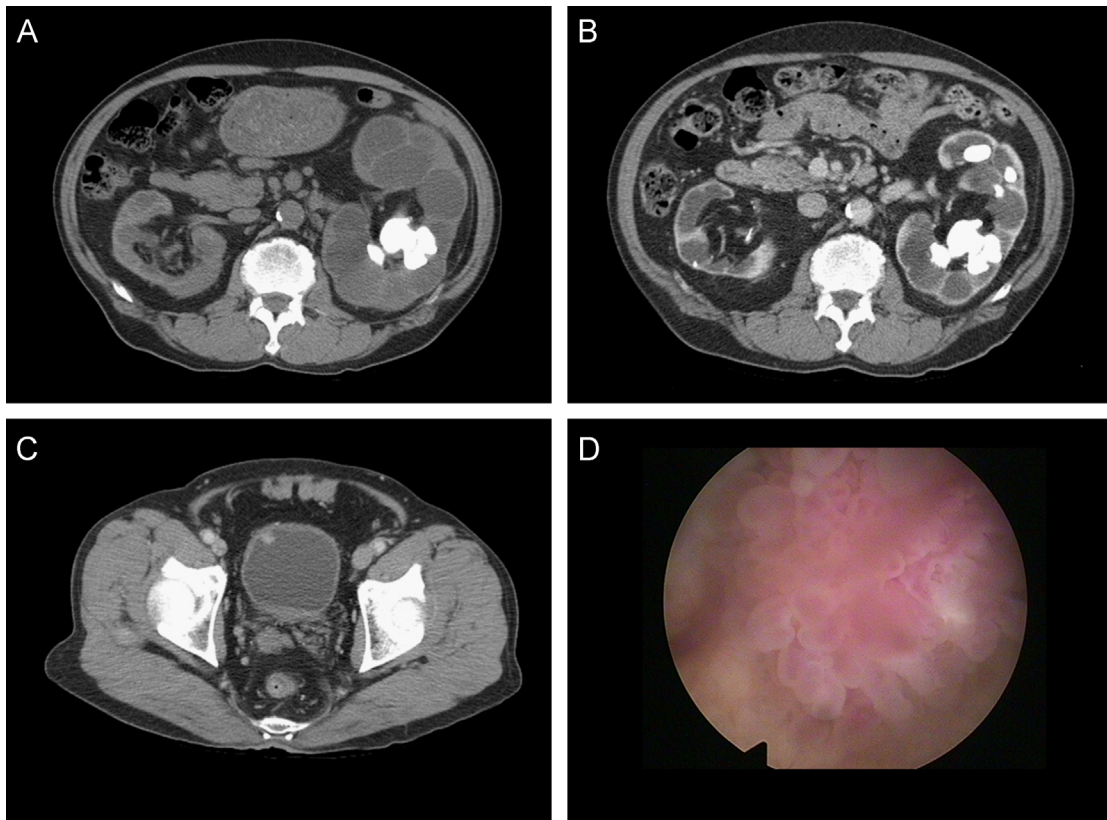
The patient's computed tomographic (CT) and cystoscopic images. (A) The patient's CT image in February 2010. Multiple renal parenchymal and renal pelvic stones with dilated calyces in both kidneys and hydronephrosis in the left kidney are shown. (B) The patient's CT image in November 2013. Multiple renal stones in the left kidney and dilated calyces and hydronephrosis are shown. The dilated calyces and hydronephrosis had not worsened compared with the CT image obtained in February 2010. (C) The patient's CT image in November 2013. A nodular lesion in the right anterior aspect of the urinary bladder is shown. (D) The patient's cystoscopic image. A solitary mass lesion on the right anterior wall of the urinary bladder is shown.
